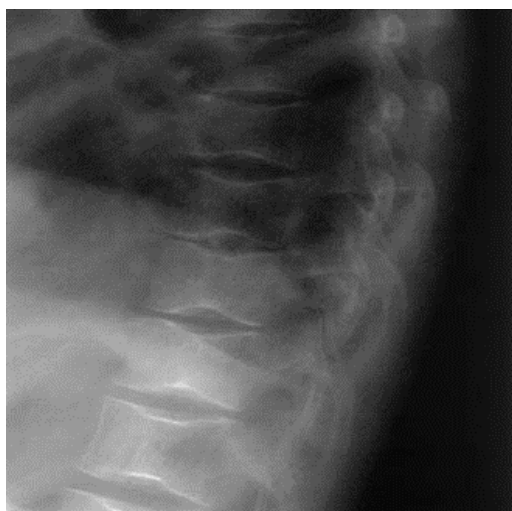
H-shaped vertebrae in a 15-year-old patient with sickle cell anemia. Lateral radiograph of the thoracolumbar junction demonstrates classic box like endplate depressions from osteonecrosis of the vertebral endplate.
